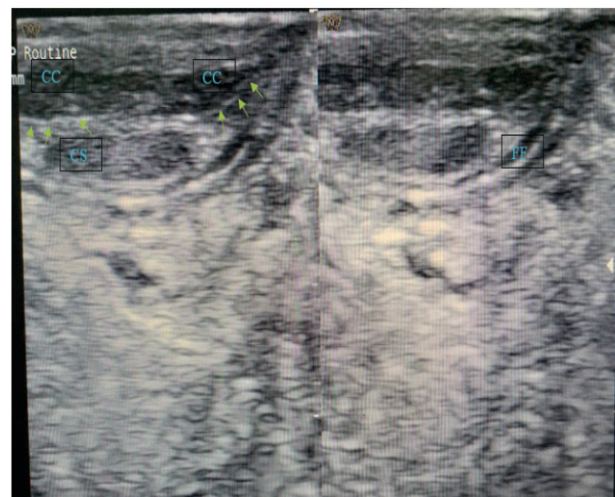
Ultrasound Imaging of the Penis. Arrow (Tunica Albuginea), CC (Corpus Cavernosum), CS (Corpus Spongiosum), FF (Free Fluid). This imaging showed tunica albuginea was intact and free fluid outside the tunica albuginea.
